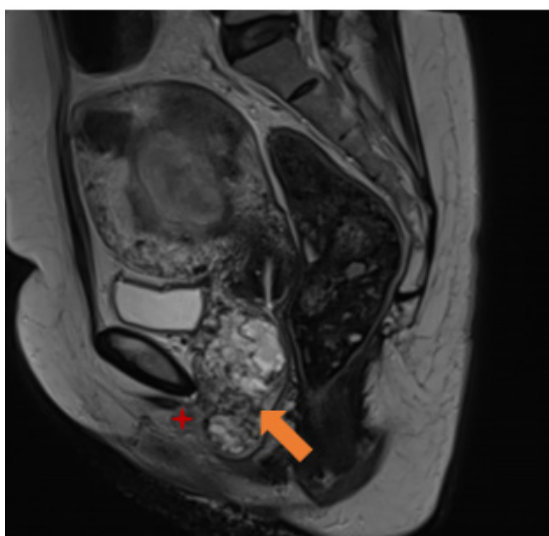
Sagittal T2-weighted image showing the extent of the lesion reaching the lower third of the vagina (orange arrow) and infiltration of the adjacent fat (red star).
